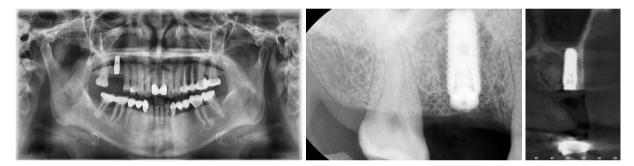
~13. Post-operative radiograph. In the post-op CT scan, the SmartBuilder is contouring an ideal shape of palatal alveolar bone and bone graft materials are placed stably under the SmartBuilder.
